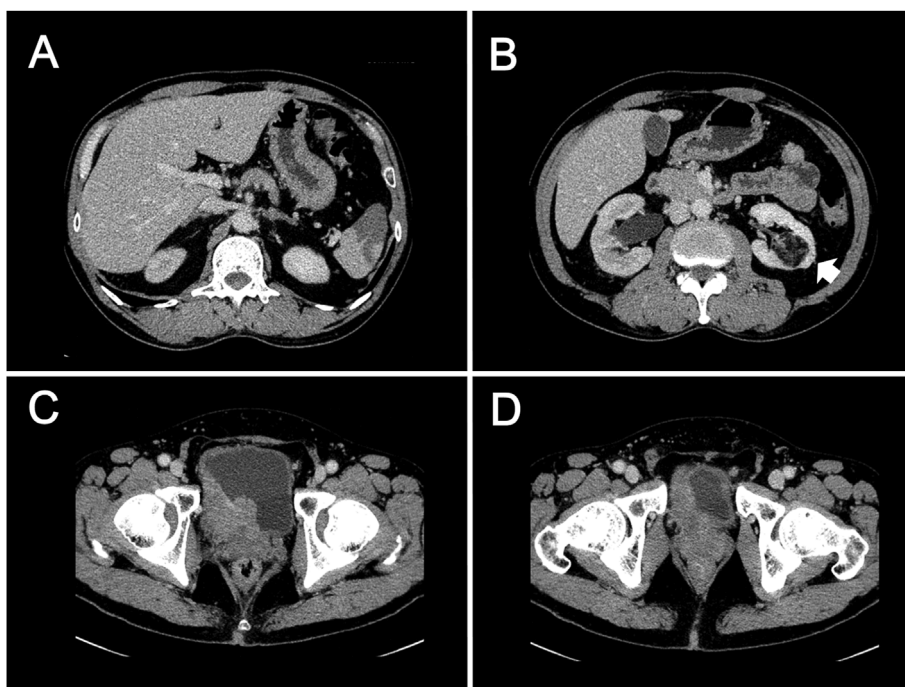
Abdominal computed tomography. Computed tomography revealed an asymptomatic splenic infarction (A), right-side hydronephrosis and an angiomyolipoma in the left kidney (white arrow) (B), large invasive bladder cancer suggesting prostate invasion with bilateral extra-iliac lymph node enlargements (C, D).
